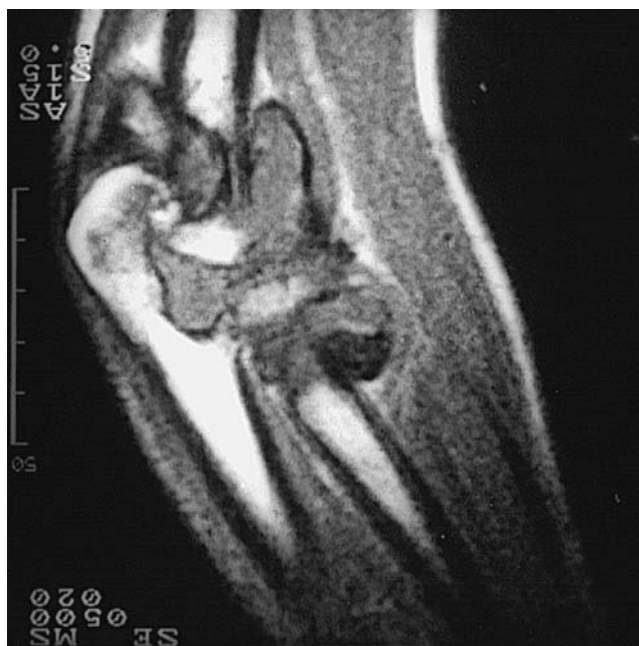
Magnetic resonance imaging (MRI) scan of an elbow showing a severe degree of chronic haemophilic synovitis.
